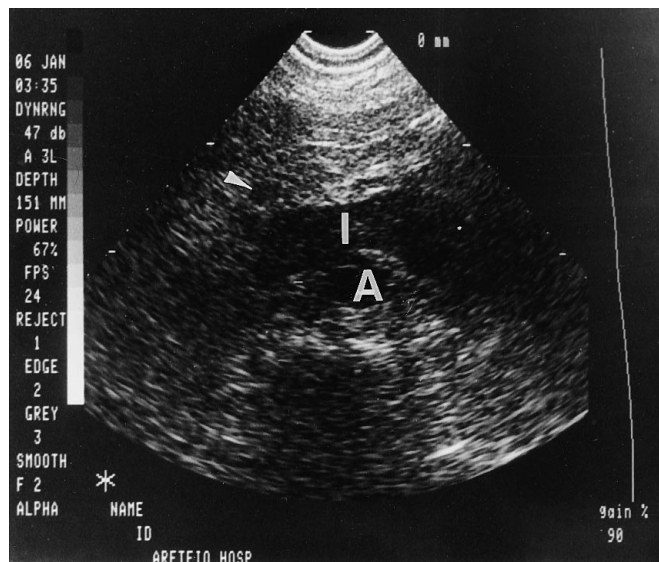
Ultrasound demonstrates the horseshoe kidney with the aorta (A) posterior to the isthmus (I) and the inferior vena cava (IVC) lying anterior to the right renal moiety (arrowhead)
